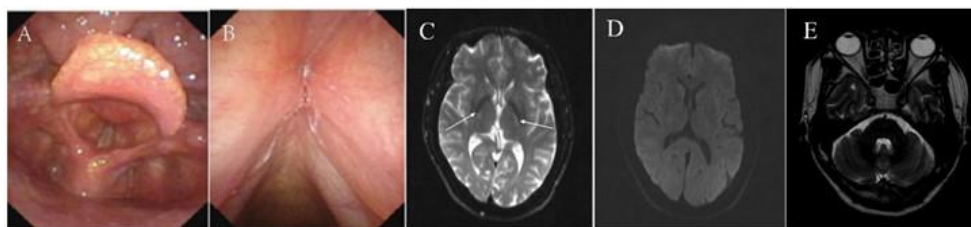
Neuroimaging and laryngoscopy findings. (A, B) Laryngoscopy showing chronic laryngitis. (C, D) Diffusion-weighted imaging (DWI) showing symmetric hyperintensities (arrows) in the posterior limbs of the bilateral internal capsules. (E) T2-weighted image showing no significant abnormalities in the cerebellar dentate nuclei.
